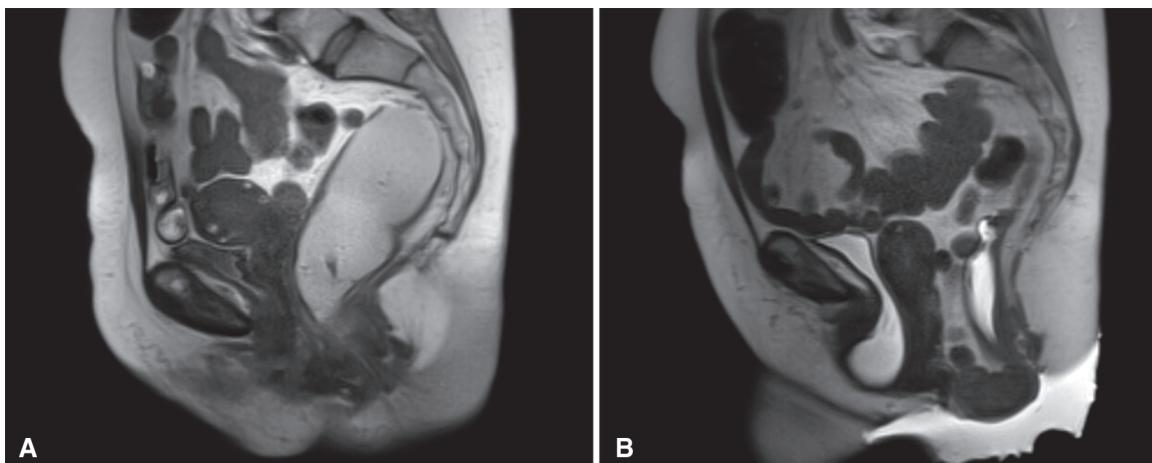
Preoperative MRI in woman with vaginal bulge symptoms and obstructed defecation. MRI defecography images before (A) and after (B) bearing down demonstrate moderate-sized cystocele and large enterocele/perineocele during evacuation.
